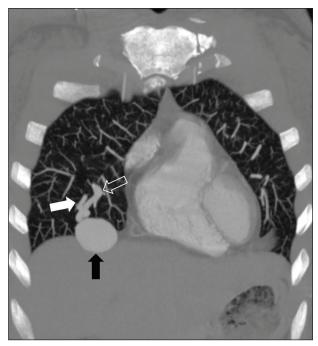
Contrast-enhanced CT of a PAVM demonstrates an FA (white arrow), nidus (black arrow), and draining vein (arrow outline).
